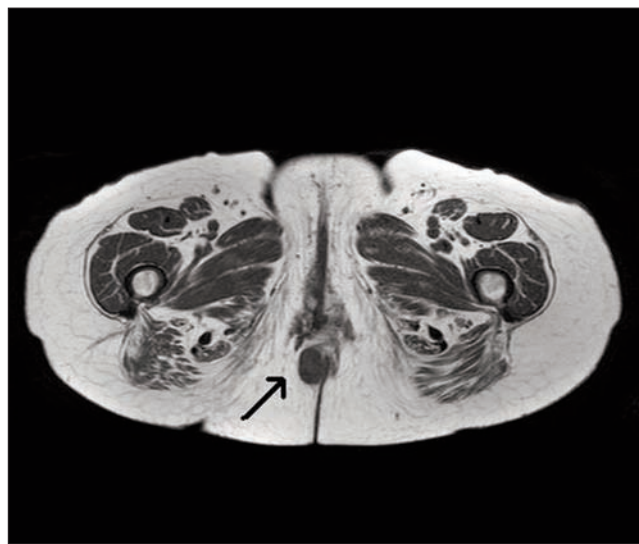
T1-weighted MRI (transverse section) allows to precisely locate the mass, revealing a small, well-defined lesion in the right anterior quadrant of the anal canal with no contact with the external anal sphincter.
